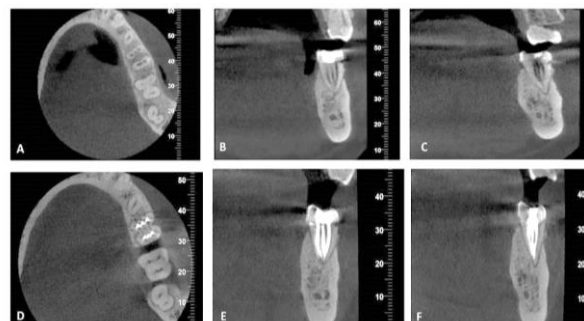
A to F:(A)Axial view CBCT image showing three canals in mesial root and distal root.(B)Coronal view CBCT image of mesial root showing three separate canals merging at apical 1/3rd of the root.(C)Coronal view CBCT image of distal root showing three separate canals merging at apical 1/3rd of the root.(D)CBCT image showing three obturated canals in mesial root and three obturated canals in distal root.(E)CBCT image of mesial root showing three obturated canals merging at apical 1/3rd of the root.(F)CBCT image of distal root showing three obturated canals merging at apical 1/3rd of the root. Working length radiographs were taken at different angulations with a file placed in each canals and confirmed with electronic apex locator (Endy 6200 by IONYX). After the initial instrumentation access cavity was temporarily restored and patient was sent to the CBCT centre. Additional canals were confirmed with the help of CBCT. [figure 2 A, 2B, 2C] Cleaning and shaping was performed at second visit using a crown-down preparation with rotary instruments (Neoendo Flex Files by Orikam) under profuse irrigation with 5% sodium hypochlorite solution. After drying the root canals with sterile paper points, obturation was carried out with gutta-percha cones (Neoendo by Orikam) using zinc oxide eugenol sealer. [figure 1 D, 1E]. Since the anatomy was unusual, CBCT image was taken to confirm the anatomy. CBCT imaging confirmed the presence of six canals with the concerned tooth. [figure 2]
